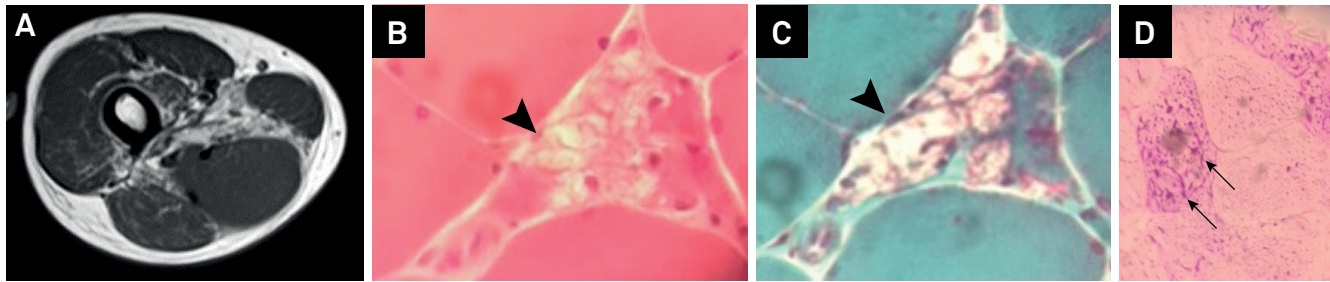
Muscle MRI and muscle biopsy findings in LOPD. (A) Right thigh muscle MRI showed marked compromise of the adductor magnus and mild involvement of the vastus medialis and vastus intermedius muscles. (B–D) Deltoid muscle biopsy showing vacuolar myopathy (black arrow-head) with PAS-positive vacuoles (black arrow).
